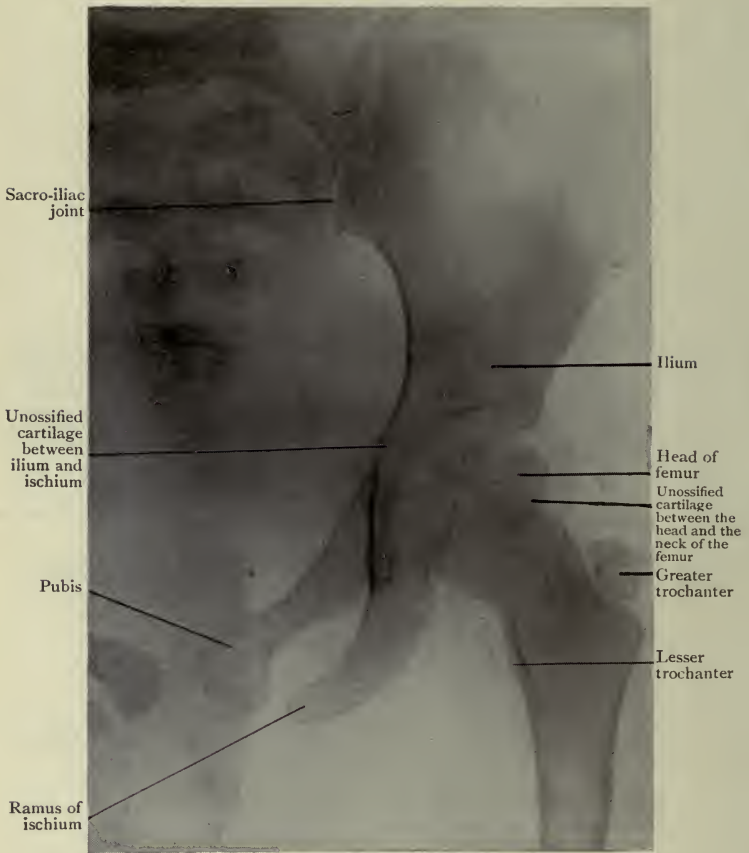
Radiograph of the Hip Region of a child.
